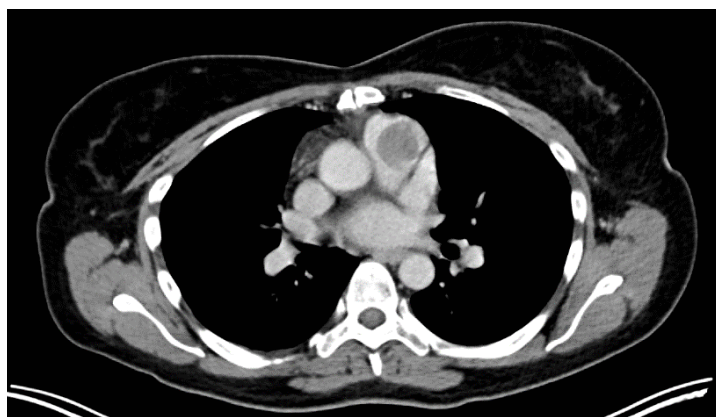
Pre-operative CT scan showing the PAS reaching into the right ventricle
